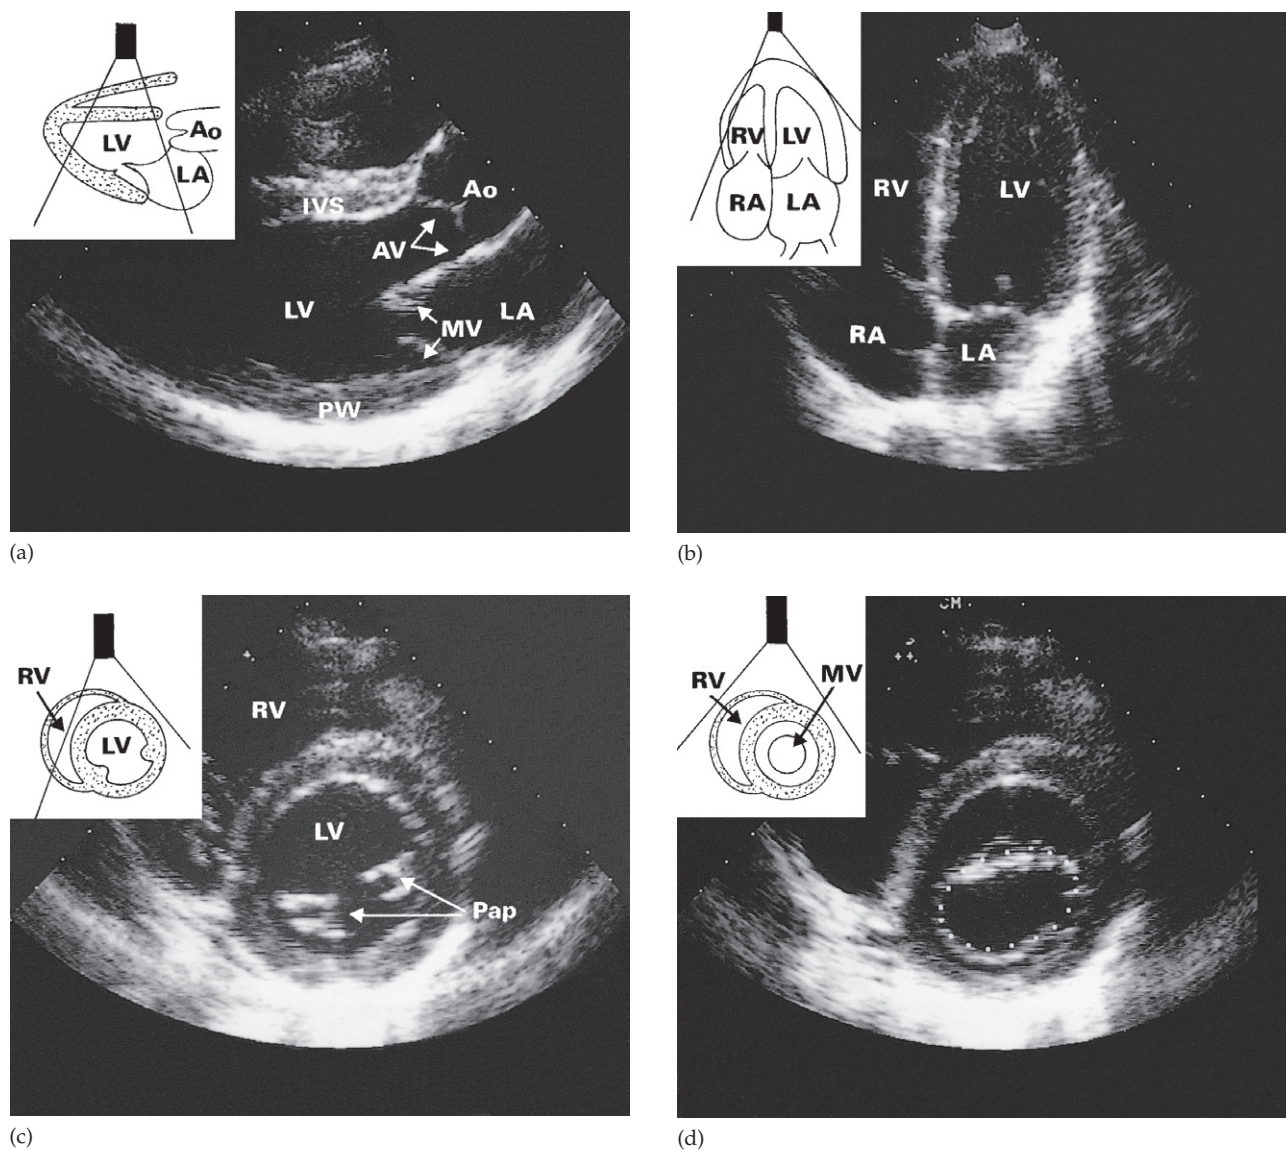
Normal two-dimensional echocardiogram. (a) Parasternal long axis view. (b) Apical four-chamber view. (c) Parasternal short axis view at the level of the papillary muscles. (d) Similar view to (c) but at the level of the mitral valve. The dots indicate the area of the open valve. Ao, aorta; AV, aortic valve; IVS, interventricular septum; LA, left atrium; LV, left ventricle; MV, mitral valve; Pap, papillary muscles; PW, posterior wall of LV; RA, right atrium; RV, right ventricle. Courtesy of Andrew A. McLeod and Mark J. Monaghan.
